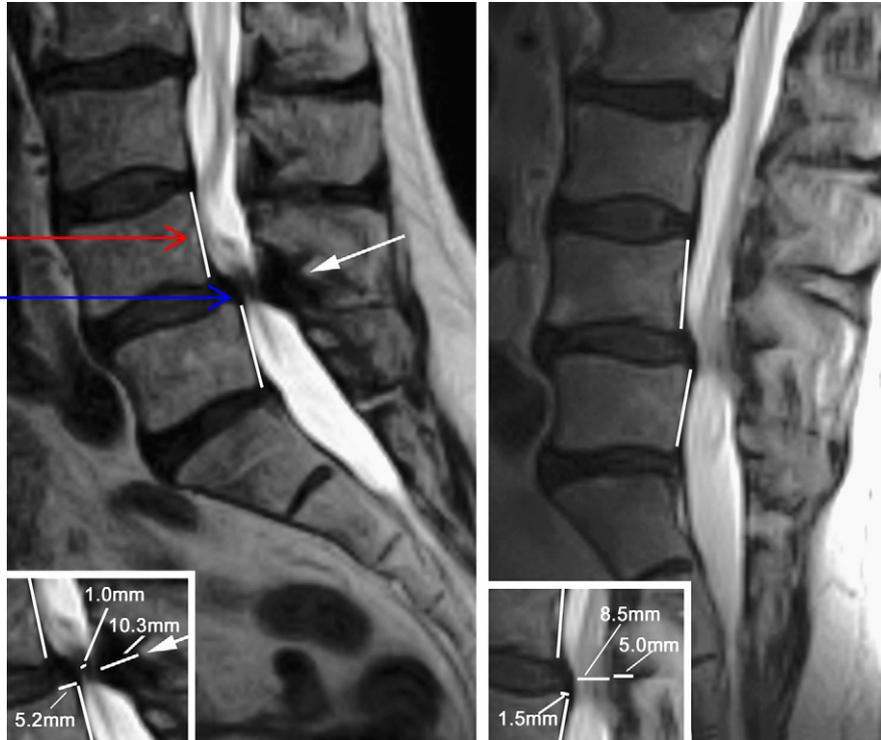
A 63-year-old man with a history of bilateral sciatica, and position-dependent lower back pain. MRI demonstrates grade 1 degenerative spondylolisthesis and translational instability with central canal stenosis. Sagittal T2W images in seated flexion and neutral positions demonstrate slightly increased forward slip with flexion (lines), associated with a greater degree of central canal stenosis (white arrow). Insets demonstrate the increase in forward slip (71.2%), increase in ligamentum flavum bugling (51.5%) and resultant reduction central canal anteroposterior diameter (88.2%) from neutral to flexed positions.
